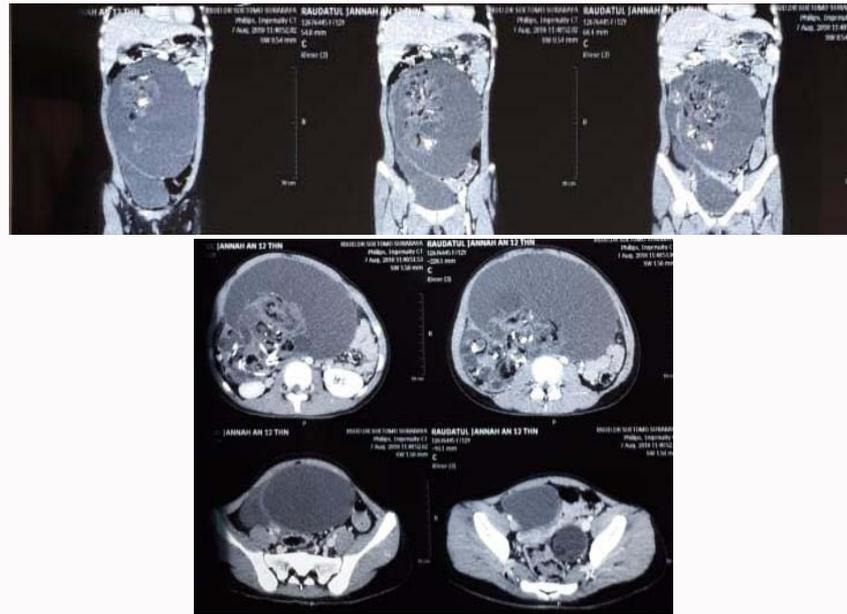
Abdominal CT of 12-year old girl with cystic abdominal mass.
